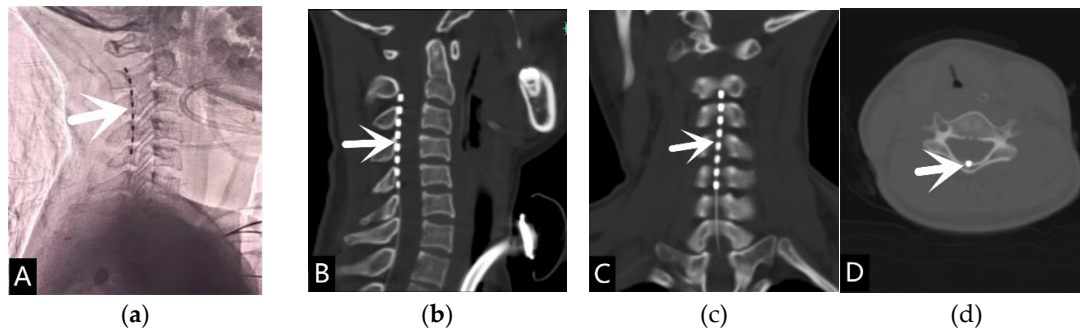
High position SCS electrode located at the level of the 2-3th cervical vertebral body. (a) Lateral view of SCS electrode shown on DSA (white arrow); (b) Sagittal CT image of SCS electrode (white arrow); (c) Coronal CT image of SCS electrode (white arrow); (d) Axial CT image of SCS electrode (white arrow).
